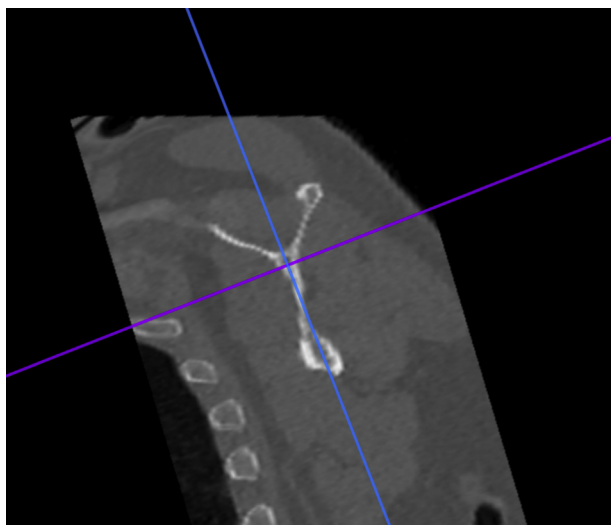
Sagittal CT image aligned with the vertical axis parallel to the vertical axis of the scapula. CT, computed tomography.
